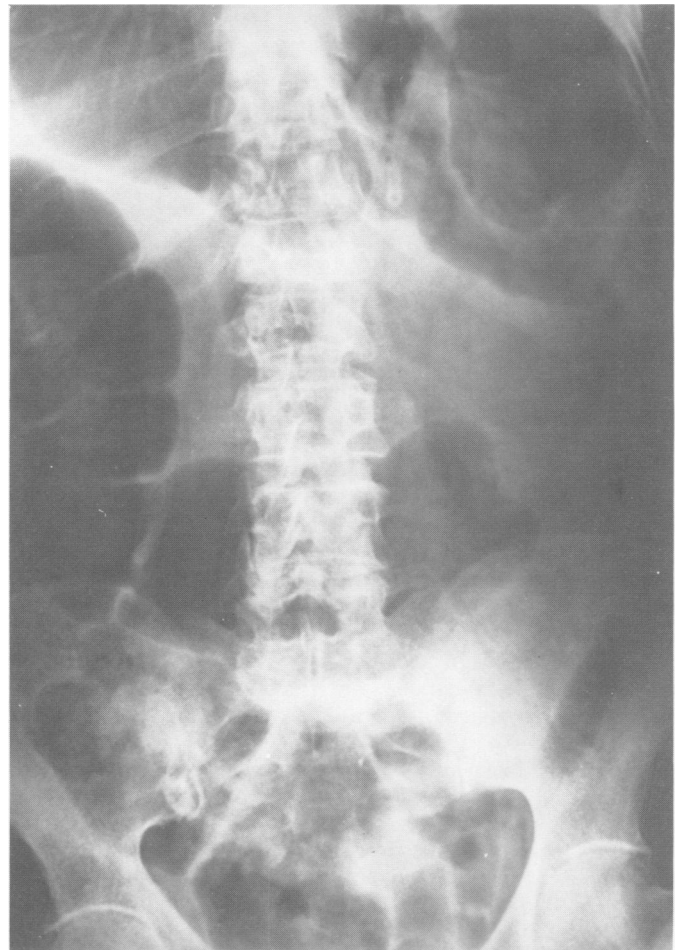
Abdominal radiograph taken immediately after endoscopic decompression of sigmoid volvulus. Residual gas is present in the uninvolved large bowel.
